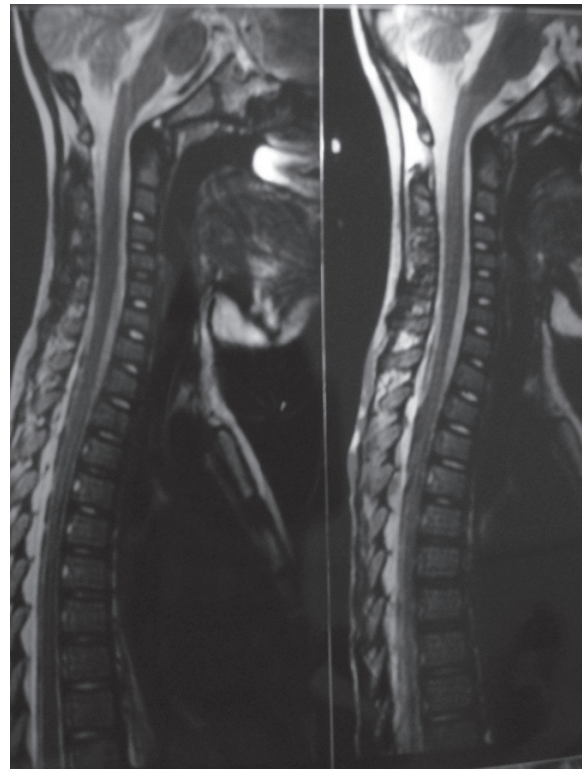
New spinal MRI scan four weeks later showing complete resolution of the lesion.
